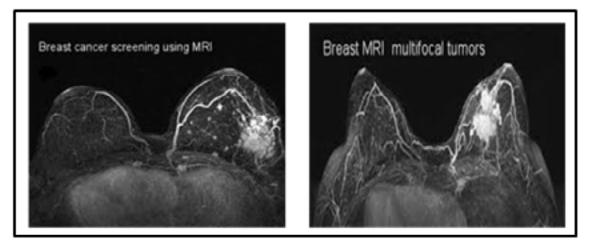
Sample MRI Breast Image
